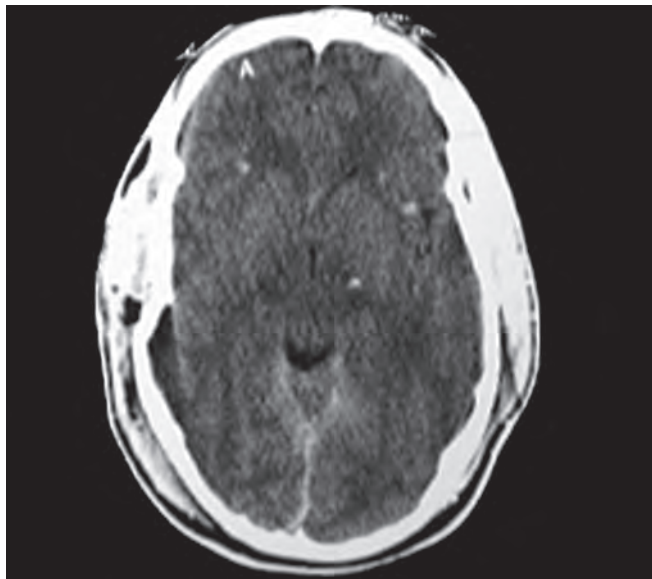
Non-contrast CT scan of a trauma patient demonstrates multiple petechial haemorrhages consistent with DAI, characteristically located at the grey-white matter interface
